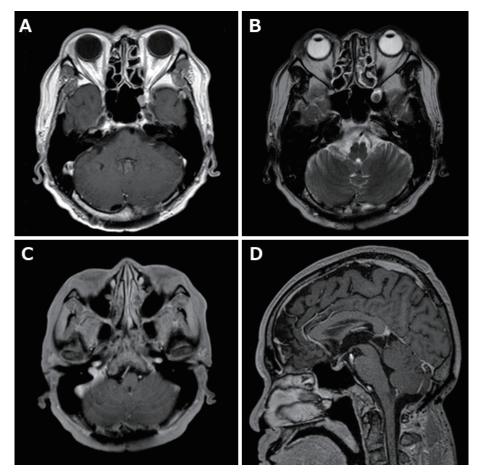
MR images 5 months after the biopsy when chemotherapy was finished. By axial T1WI (A), T2WI (B), Gd-T1WI (C), and a sagittal Gd-T1WI (D), no apparent residual tumor can be detected.
